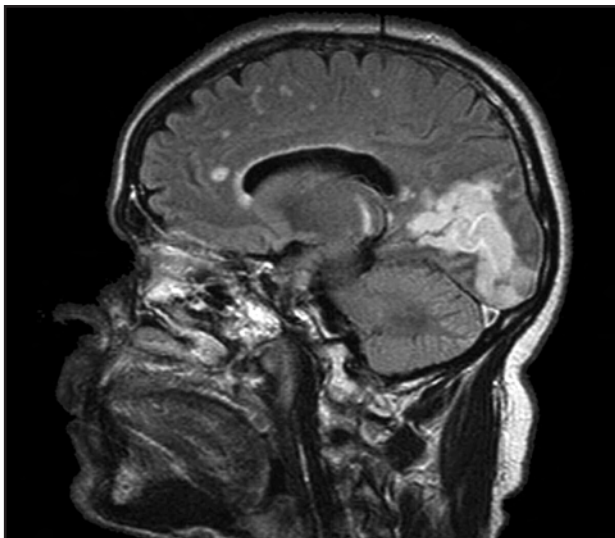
Sagittal MRI scan showing a left medial occipital lobe lesion involving the striate cortex from the parieto-occipital sulcus to the posterior pole including both the cuneus and lingual gyri.
